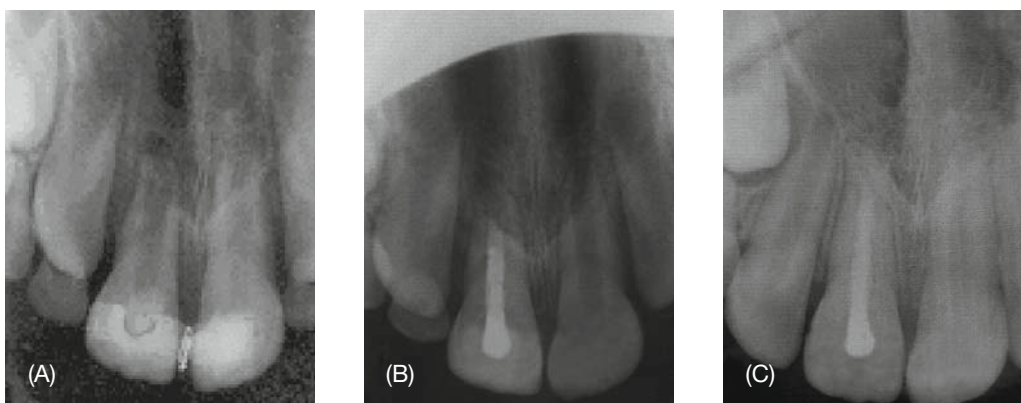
Periapical radiographs of Case 2
